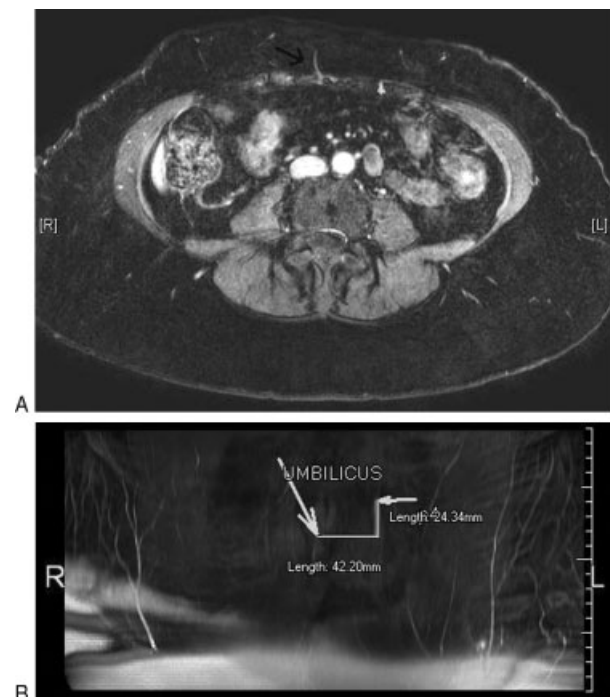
(A) Abdominal magnetic resonance imaging angiography (MRA) (axial view). Arrow points to a large perforator. (B) Abdominal MRA showing coordinate measurements of the perforator in relation to the umbilicus.
